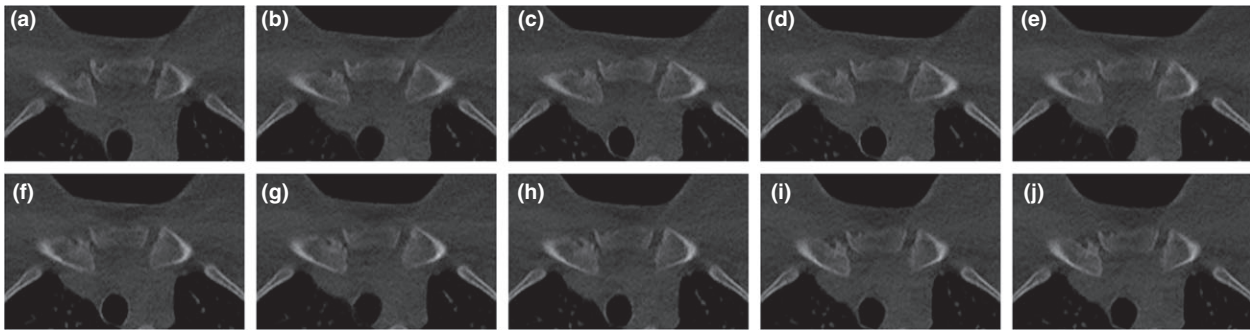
Dynamic 4D CT scans (with 3D reconstructed images taken at regular time intervals shown in panels a–j) of both sternoclavicular joints in patient 1 demonstrated significantly increased rotation of the right medial clavicle from neutral position to shoulder retraction, confirming instability. The asymptomatic left sternoclavicular joint showed minimal rotation of the medial clavicle.
